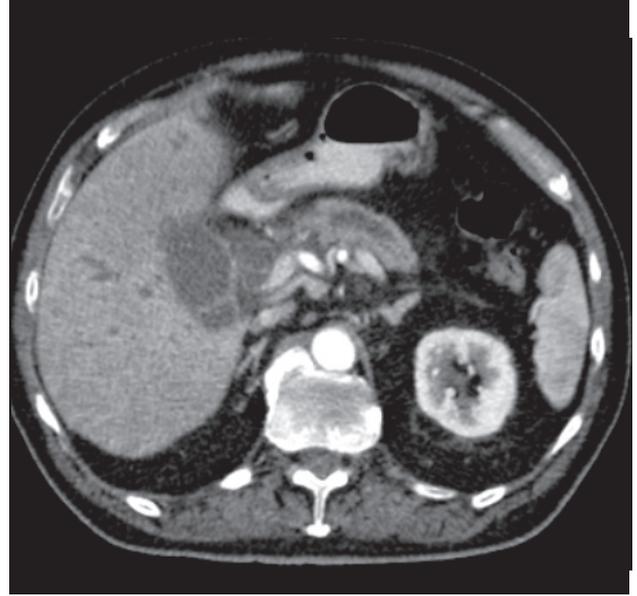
Axial enhanced CT image of the abdomen.
